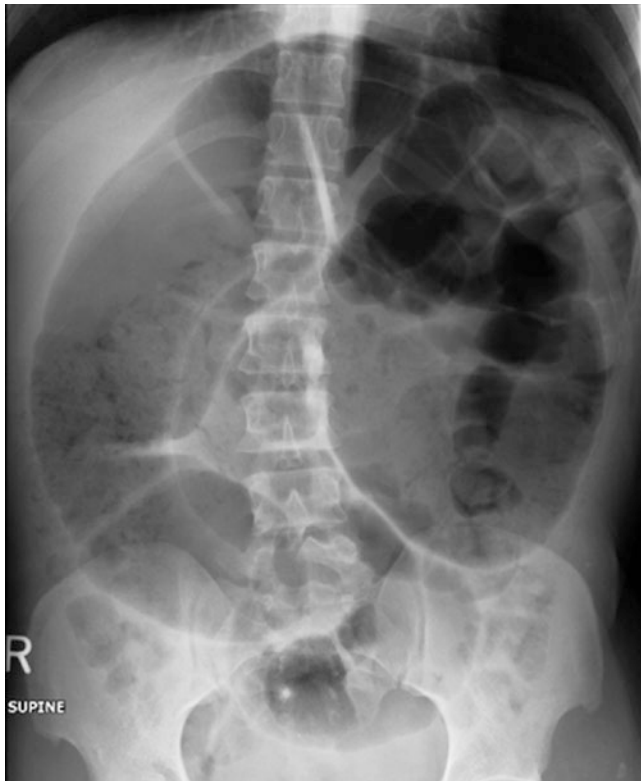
Abdominal radiograph showing a typical sigmoid volvulus prior to decompression. (Courtesy of Daniel L. Feingold, MD)
